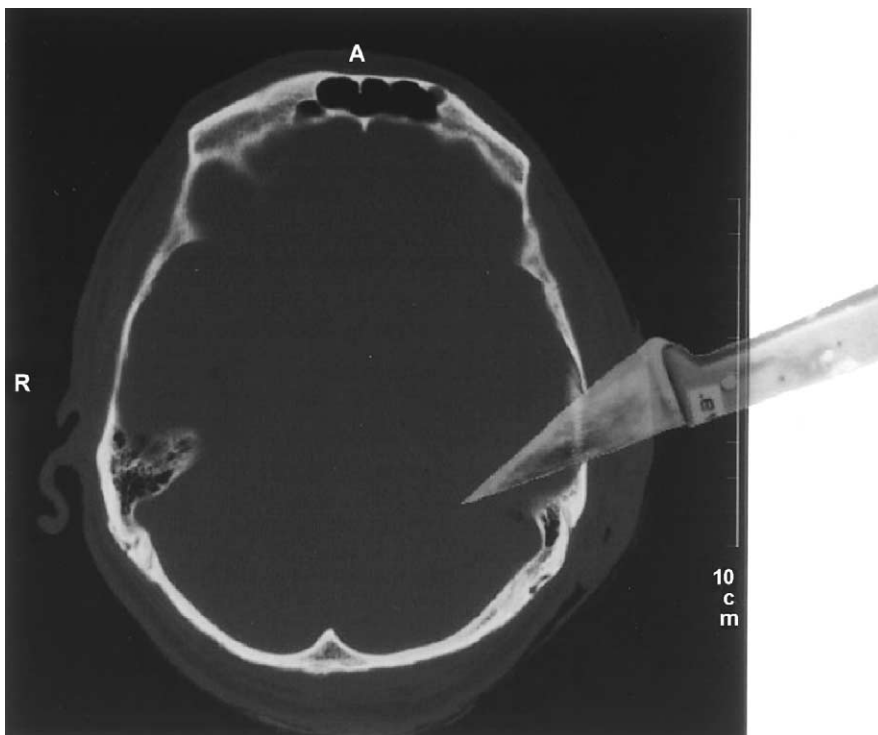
Bone window of the CT scan shown in Fig. 3 with superimposed weapon. The depth of insertion corresponds to the width of the slot fracture.
